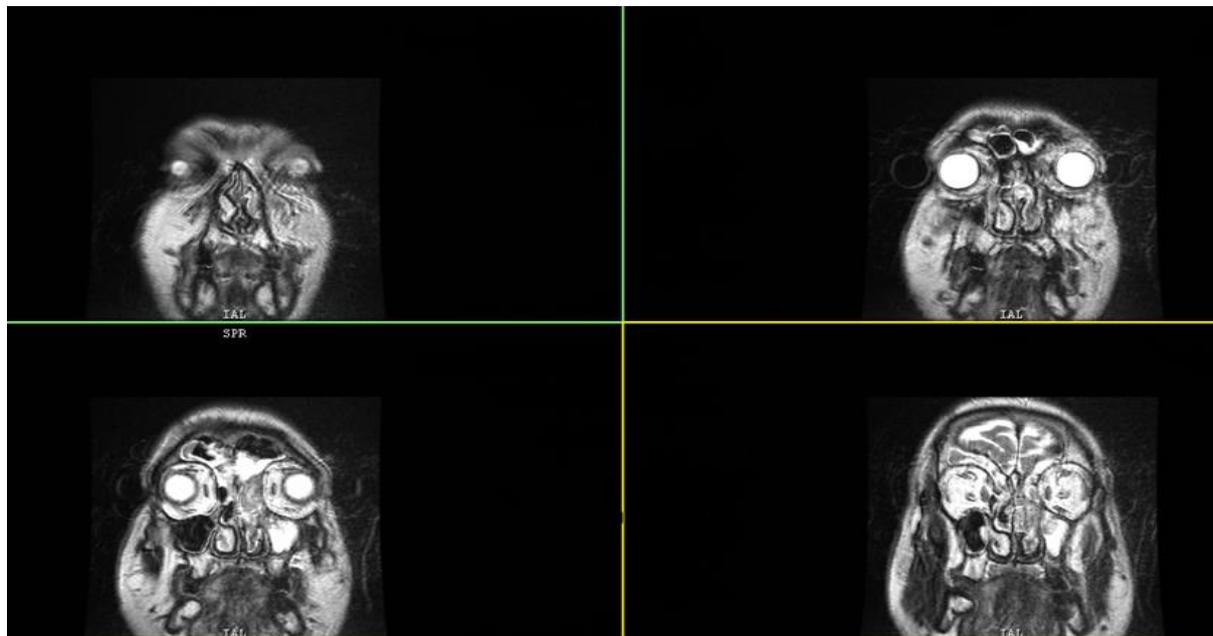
T1 coronal MRI showing hypointensity in the left maxillary, ethmoidal and frontal sinuses with breakdown of the left lamina papyracea.
